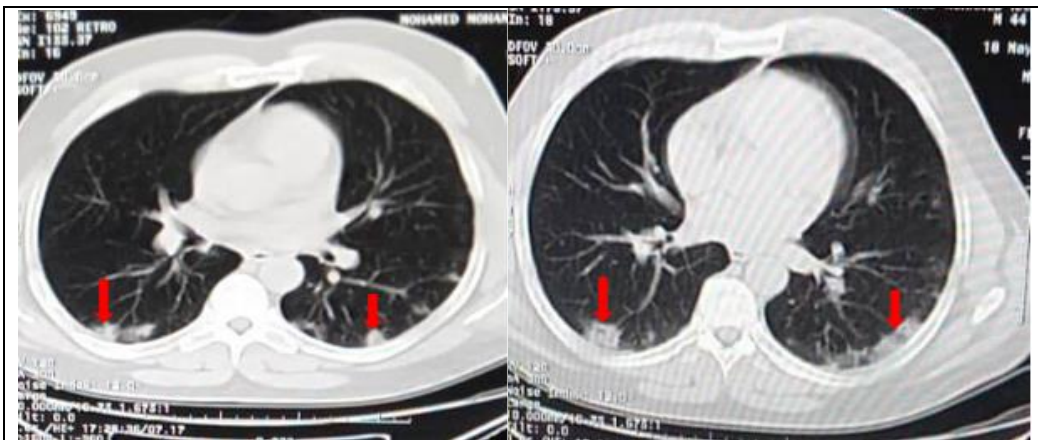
44 years old male who has experienced cough, chest pain and mild fever for 3 days; image (A, B) Plain axial CT images (chest window) showed multiple bilateral subpleural ground glass opacities (GGO) (arrows).
